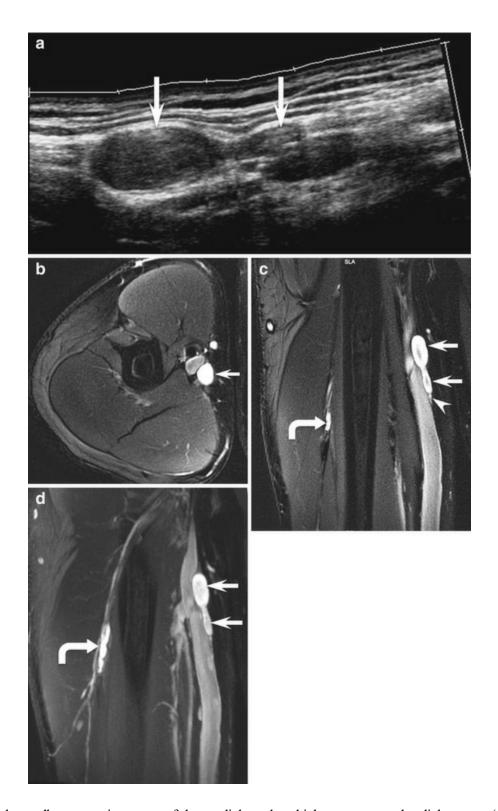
Multiple small neurogenic tumors of the medial antebrachial cutaneous and radial nerves. (a) Ultrasound shows two small neurogenic tumors (arrows) affecting the medial antebrachial cutaneous nerve. (b) Axial, (c) coronal and (d) coronal multiplanar volume reformation fat-suppressed T2-weighted 3 T MRI show two small nerve tumors (arrows) affecting the medial antebrachial cutaneous nerve (arrowhead) and tiny neurogenic tumors of the radial nerve (curved arrow). Note the vascular inflow signal reduction and the absence of ghost artifacts caused by vascular pulsatility facilitating the depiction of the tumors
